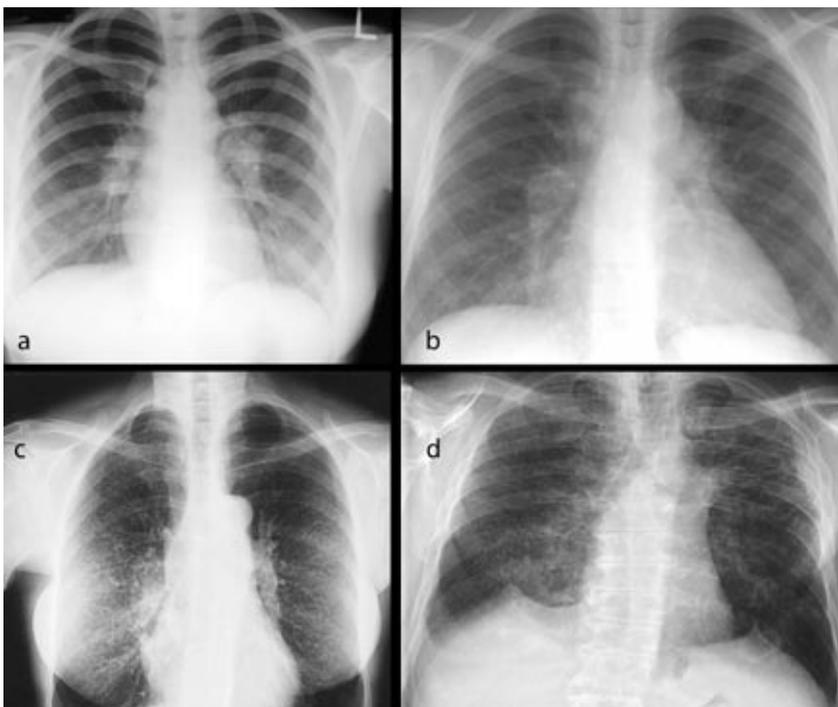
Patients with sarcoidosis may present at any radiographic stage. Panel (a): stage 1—bilateral hilar lymphadenopathy only (likelihood of spontaneous remission 55-90%); panel (b): stage 2—bilateral hilar lymphadenopathy plus pulmonary infiltrates (40-70%); panel (c): stage 3—pulmonary infiltrates only (10-20%); panel (d): stage 4—pulmonary fibrosis (0%)
